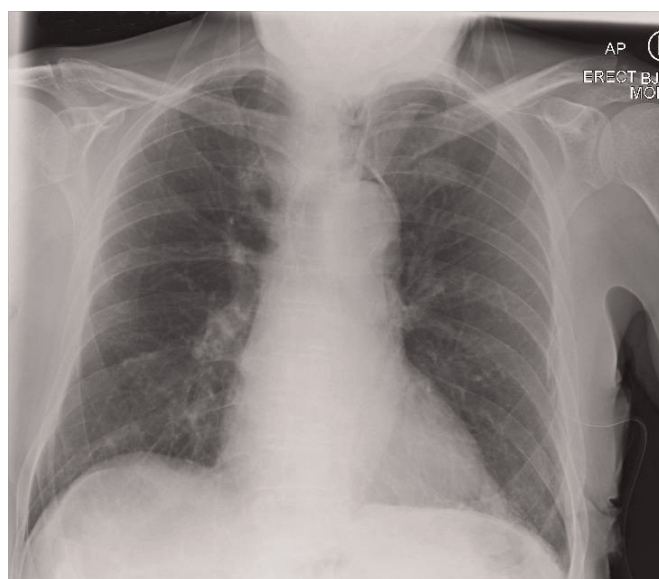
Chest radiograph showing a left-sided pneumothorax.
